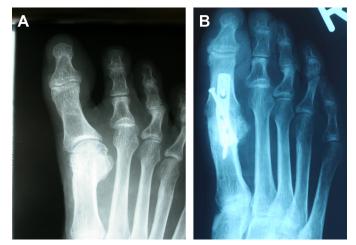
A 69-year-old woman with rigid hallux varus deformity following Chevron osteotomy. (*A*) Preoperative AP radiograph. (*B*) Revision with MTP fusion.
